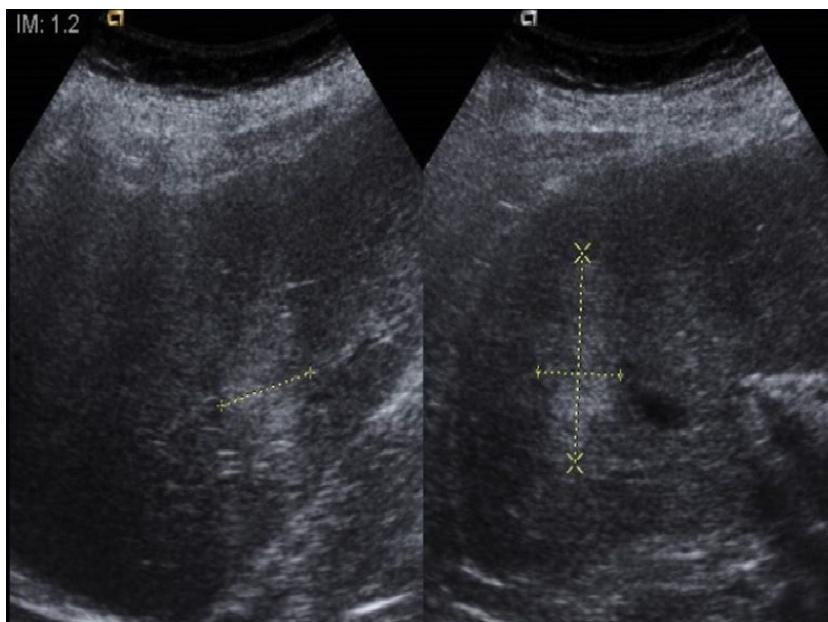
Abdominal ultrasound showing a 4 × 5 cm mass in liver.
